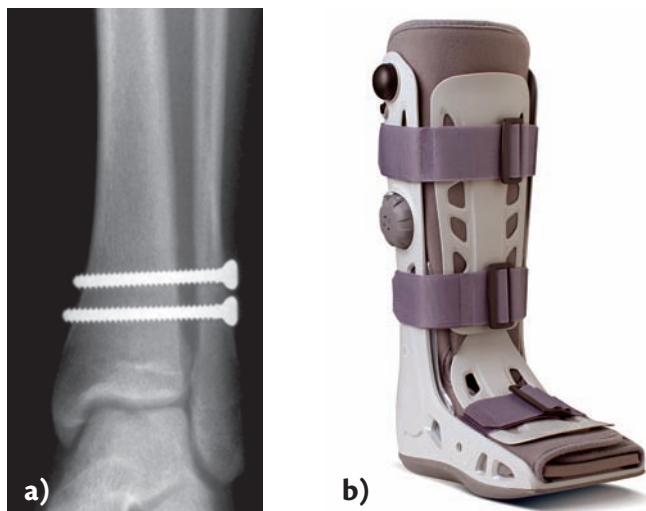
Injury to the syndesmosis, i.e. the tibiofibular ligaments and the interosseous membrane (high ankle sprain). When there is a complete tear the ligament ends can be sutured together and a temporary fixation of the tibia and the fibula can be made with screws. a) Fixation with screws seen from anterior on X-ray; b) a lower leg orthosis/walking boot to be used after surgery for this injury (with permission, from DJO, LLC. All rights reserved).
